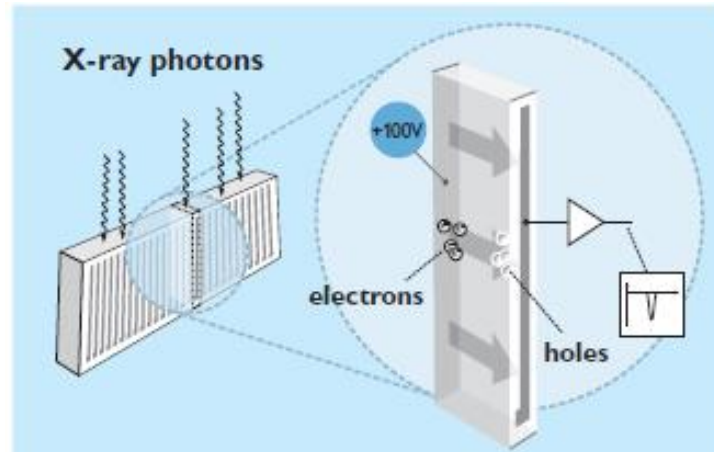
Conversion of X-ray photon energy to electrical signal
